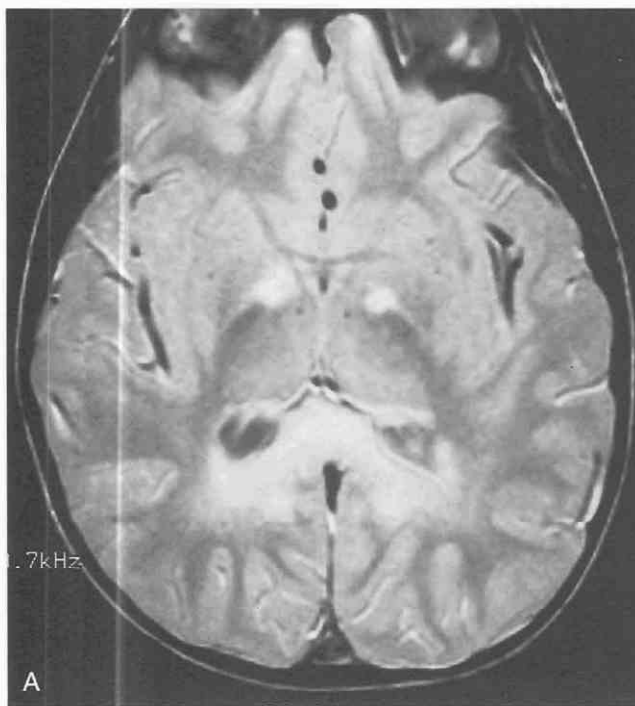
X-linked classical adrenoleukodystrophy (ALD) in a 5-year-old boy. *A*, Axial proton-density image with typical demyelination of the posterior corpus callosum and contiguous deep parietal white matter. Note also the bilateral corticospinal tract involvement. *B*, Note contrast enhancement of the splenium of the corpus callosum on the coronal T1-weighted image.
